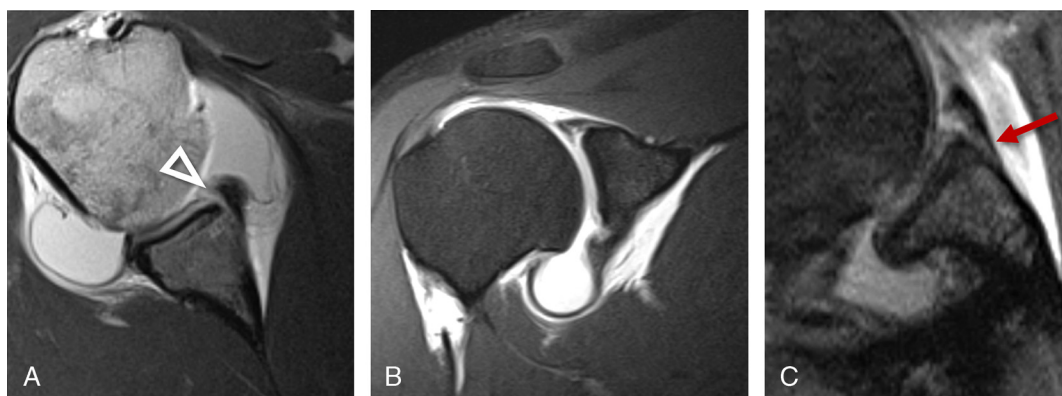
High-resolution MR arthrography image of the right shoulder with a T1-weighted axial image (A), a fat-saturated coronal T2-weighted image (B), and an additional fat-saturated T2-weighted image (C) obtained with abduction and external rotation positioning. Images in standard positioning demonstrate an anteroinferior tear of the glenoid labrum (arrowhead in A), consistent with anterior glenohumeral instability. Abduction and external rotation images demonstrate stripping of the periosteum (arrow in C), consistent with a Perthes-type lesion. The images were obtained using a high-resolution $0.6 \times 0.4 \times 0.2$ -mm 2D TSE protocol after the injection intra-articular contrast at 3 T with a dedicated 16-element shoulder coil and a parallel imaging acceleration factor of 2. Figure 1 can be viewed online in color at www.investigativeradiology.com.
